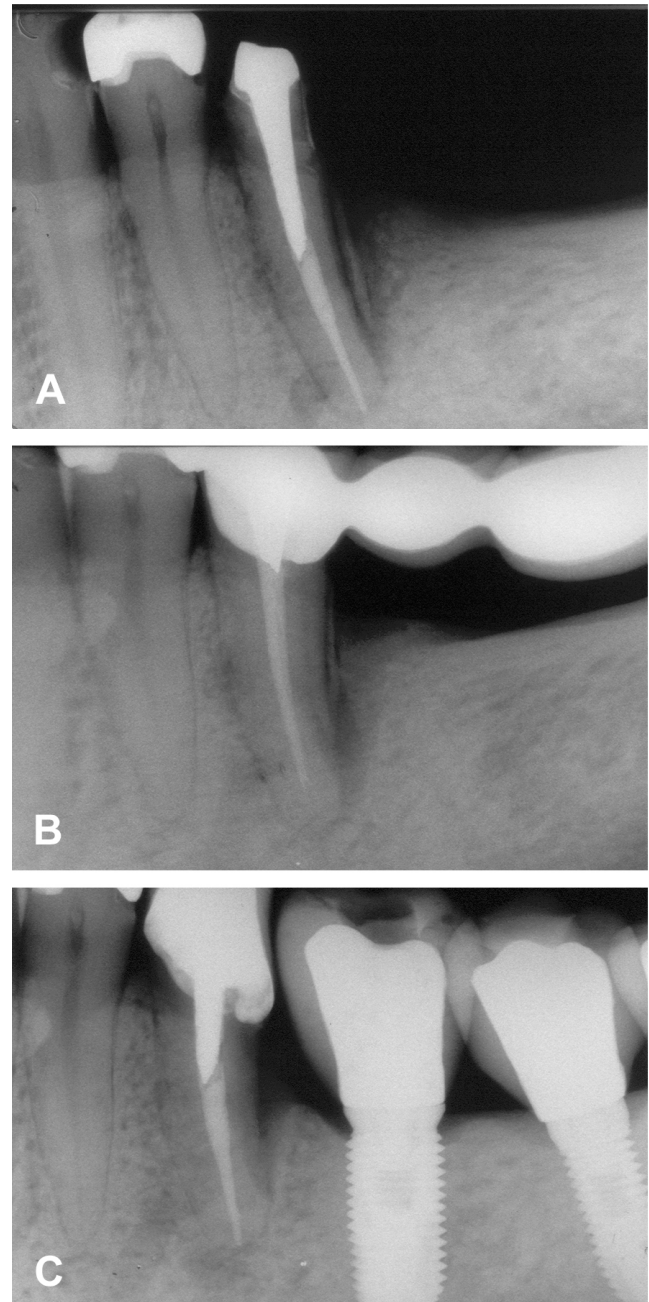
Periapical radiographs showing: (A) radiopaque aspect of the distal fragment in the mandibular left second premolar, suggesting cemental tear; (B) one year before the fragment removal; and (C) satisfactory aspect on the alveolar bone twenty four months after removal of the cemental tear.
